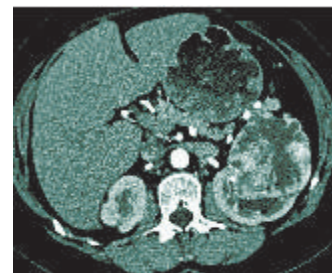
CT Scan of RCC—right kidney
